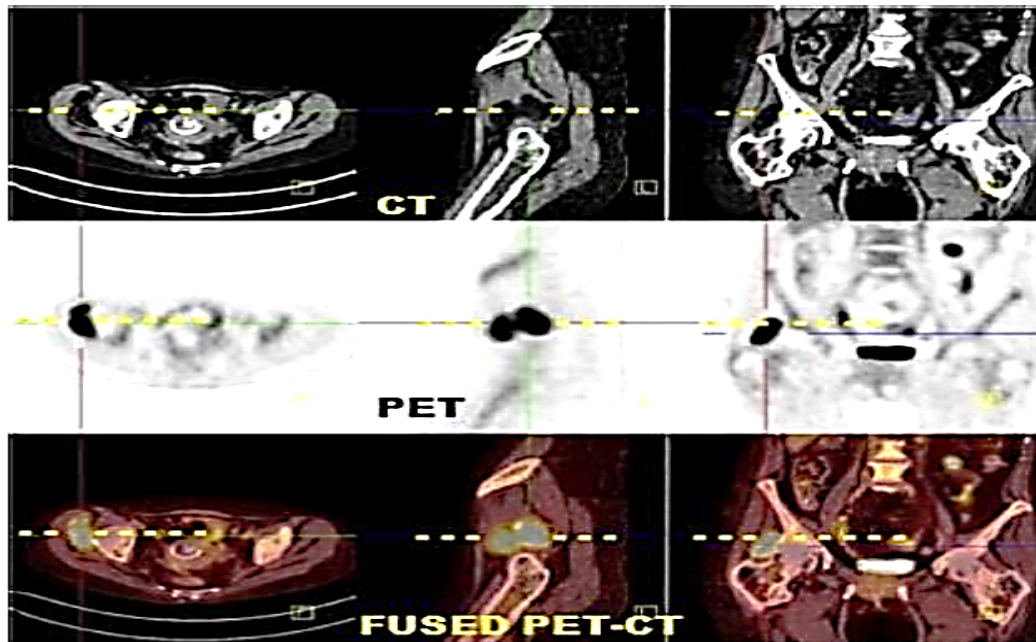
Fused ¹⁸F FDG PET-CT (multiplanar), 3 months post-treatment: FDG-avid fat-density lesion in the right gluteal region with SUVmax of 9.9 g/dL
